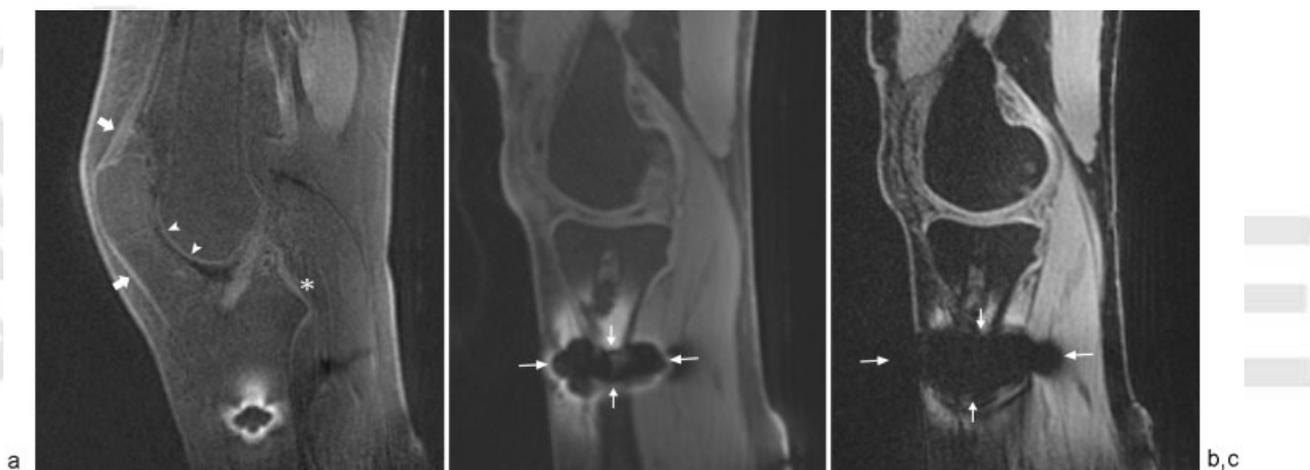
Ultrashort TE (UTE) MR imaging after anterior cruciate ligament (ACL) reconstruction. (a) UTE subtraction image (same patient as Fig. 1) shows high signal intensity of the ACL graft. High-intensity linear signal near the osteochondral junction at the trochlea (arrowheads), extensor apparatus (arrows), and posterior cruciate ligament (asterisk) can also be seen. (b) Sagittal UTE images with 60 μ s and (c) 3.92 ms TEs show more pronounced dephasing artifact surrounding hardware fixation at the longer TE.
